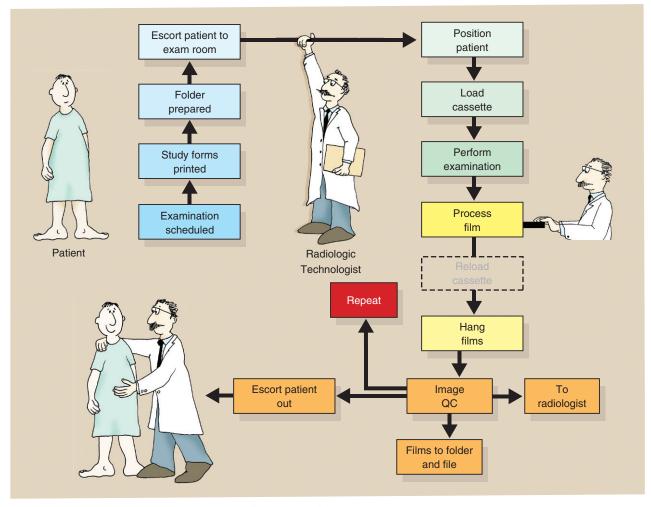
The transition from screen-film radiography to computed radiography (CR) removes one step from the radiography workload process.
